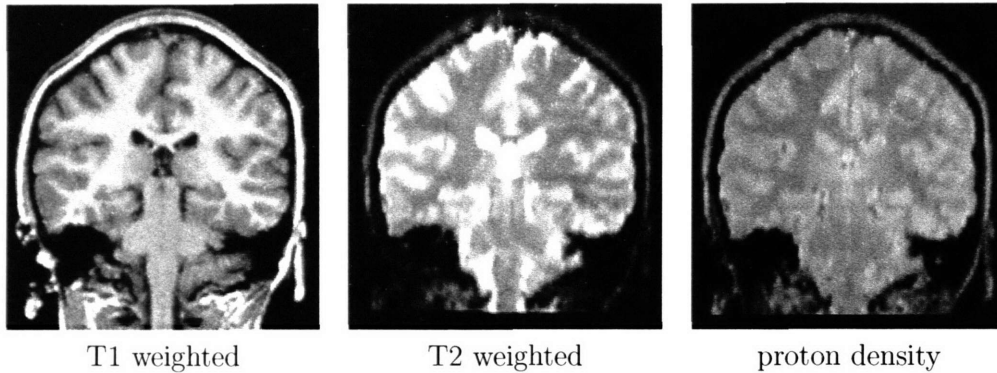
Examples of different types of magnetic resonance images that are often used by neuroscientist to better understand diseases. The T1-weighted image was produced through a 3D spoiled gradient-recalled acquisition sequence. The T2-weighted and proton density images were acquired through a double-echo spin-echo sequence resulting in 2D multi slices throughout the brain.
